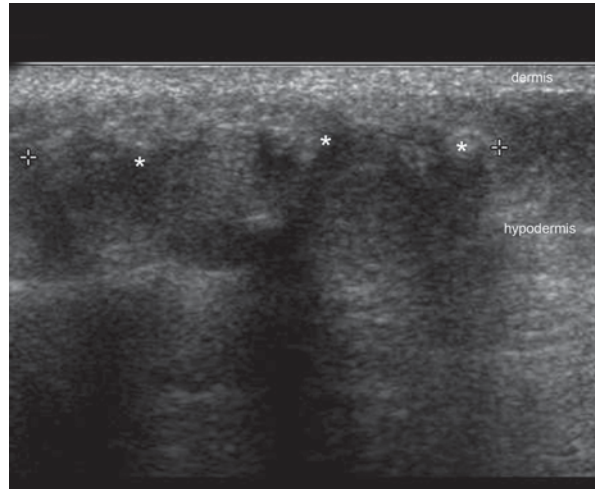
Morphea. a Active phase (*color Doppler; transverse view; right cheek*) shows thickening and decreased echogenicity of the dermis (*) with increased echogenicity of the underlying hypodermis (o). A vessel is observed in the dermal part of the lesion (arrow). b Atrophy phase (*gray scale; frontal region; transverse view*) demonstrates lack of fatty tissue in the hypodermis (*, between markers) in the lesional area
